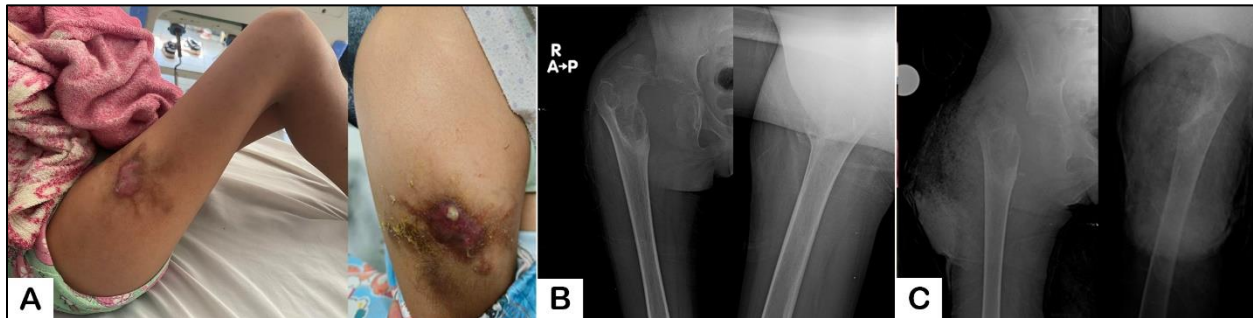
Preoperative and immediate postoperative findings. (A) Clinical photographs demonstrating a draining sinus over the proximal anterior thigh with surrounding soft tissue inflammation. (B) Preoperative anteroposterior radiographs of the right hip showing osteolytic changes in the proximal femur with superolateral displacement of the femoral head. (C) Immediate postoperative radiograph following the Girdlestone procedure.
